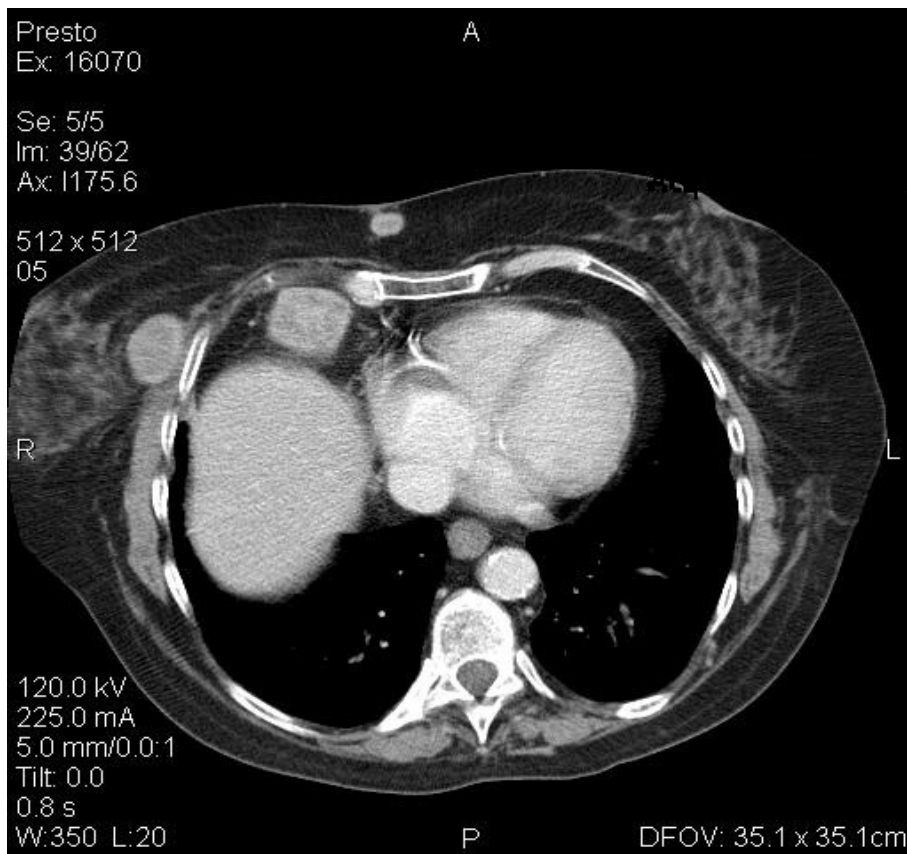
Postcontrast CT, axial section, secondary lymphogenic determinations, left axillar, right breast and inter-mammary chain
